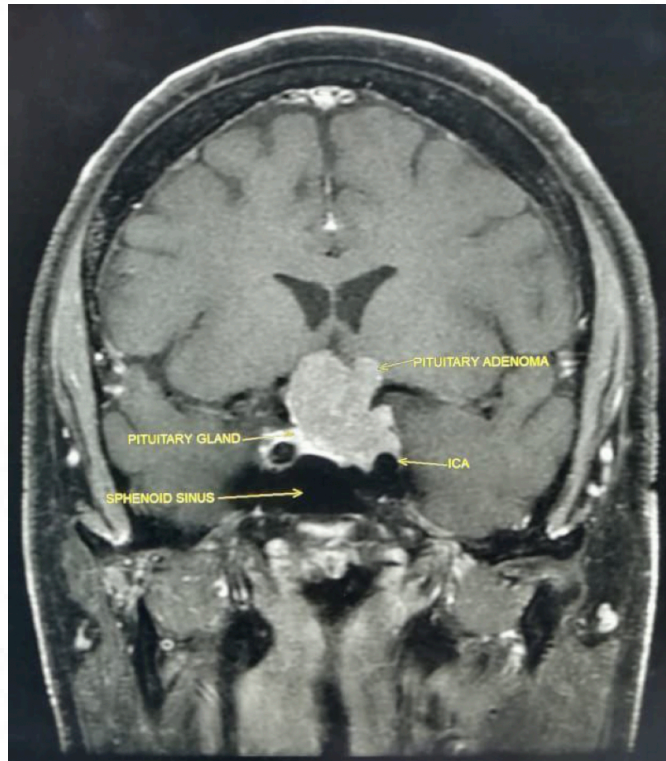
shows the MRI - coronal T1 post-contrast image of our patient showing a giant pituitary adenoma
